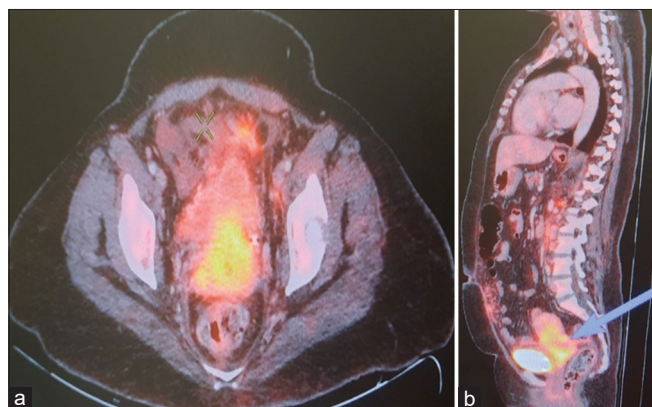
(a and b) Baseline PET CT scan showing active primary neoplastic pathology involving cervix, upper 1/3 of vagina and lower half of uterine body and anterior rectal wall
